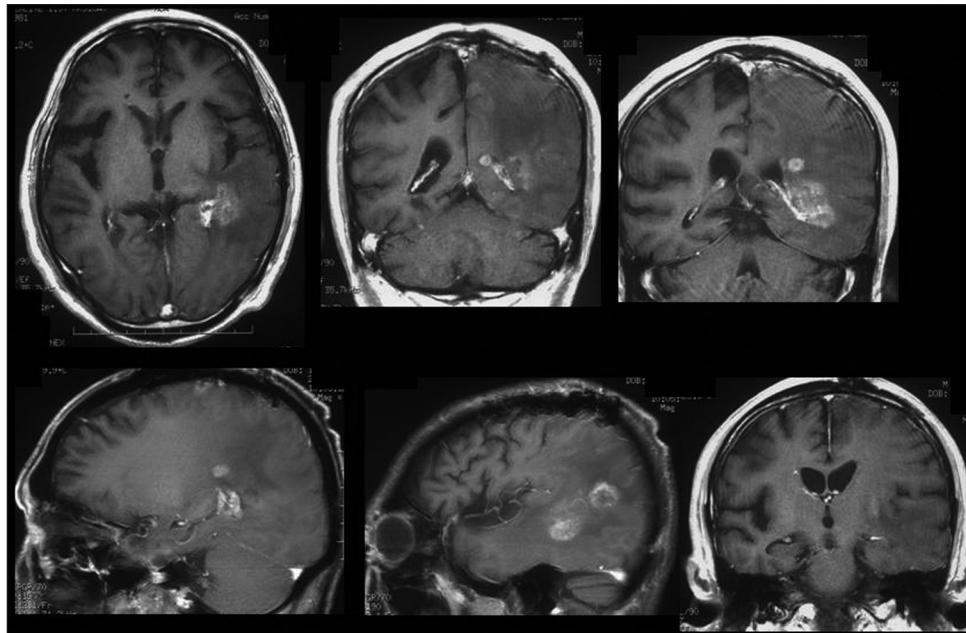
MRI after radiotherapy 50Gy and Temozolomide of 120mg daily for 42 days. Although, lessening of the mass effect of left parietal tumor was observed, enlargement of the paraventricular tumor was seen, which seemed to be pseudoprogression
